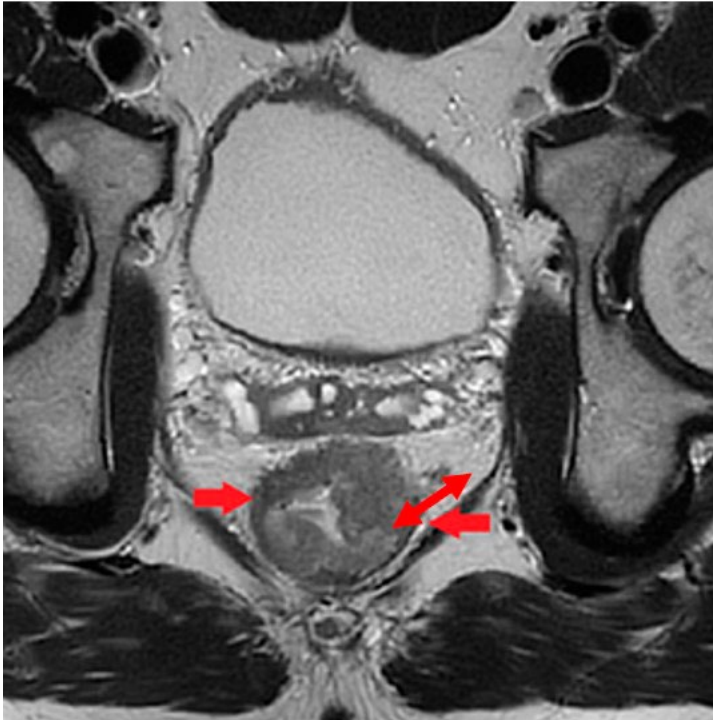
Measurement of tumor circumferential position using magnetic resonance imaging
